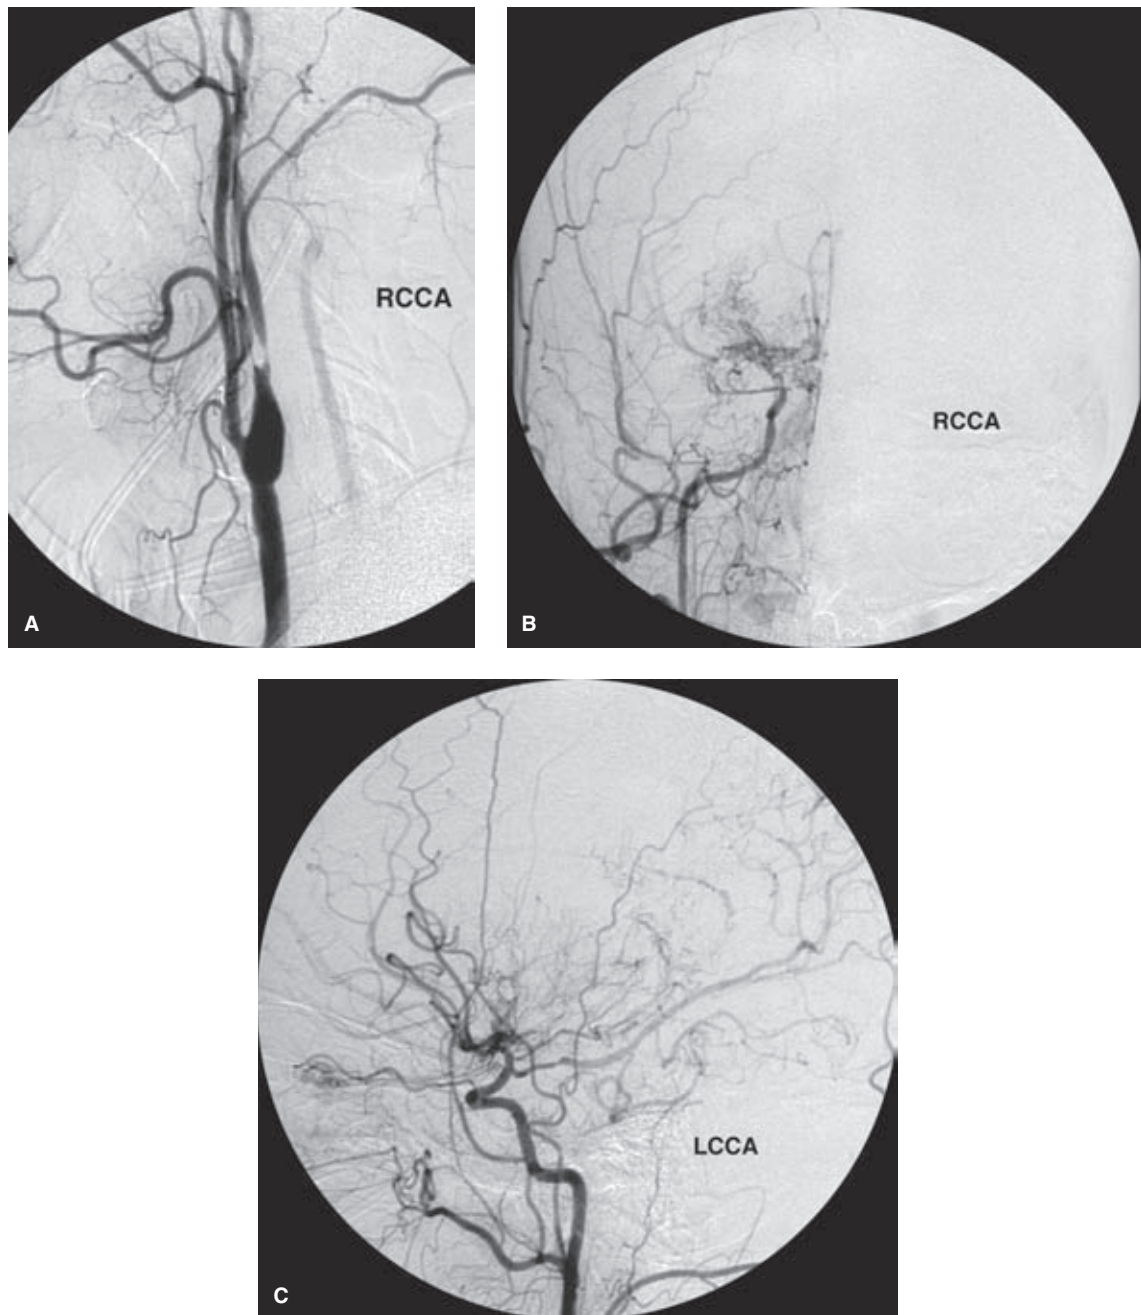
(A–C) Symptomatic carotid stenosis possibly better not treated by stenting. A 46-year-old female with right amaurosis fugax and left hemispheric ischemic symptoms, 5 years status post previous right carotid endarterectomy, was referred for treatment of the right carotid artery and evaluation of the left. The right carotid bifurcation (A) shows a severe stenosis as predicted from the Doppler examination, but the surprising finding was the unsuspected Moyamoya pattern of intracranial flow bilaterally (B and C). While an angioplasty and stent of the right internal carotid artery might relieve the symptoms of amaurosis fugax on that side, the significance of those symptoms lies in their prediction of the risk of stroke. These data from NASCET are probably not applicable to a patient with Moyamoya occlusive disease. Furthermore, the question of whether reopening the right carotid system might induce a hyperperfusion injury in the right hemisphere needs to be considered. A 2-mm angioplasty of the right internal carotid artery was performed, but this did not seem to suggest the opening of a middle or anterior cerebral artery intracranially, and more definitive endovascular treatment was therefore not pursued in this patient as a result.
